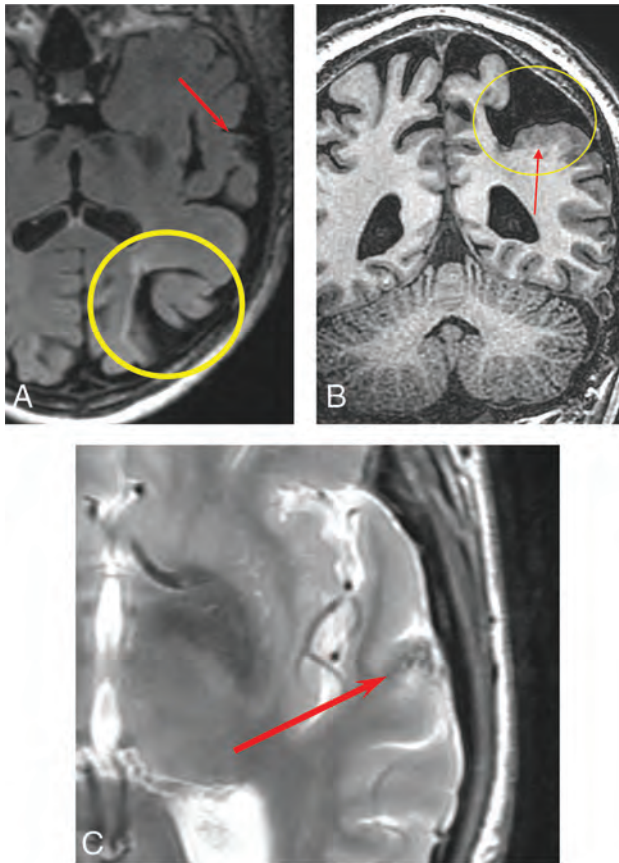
An 80-year-old man with HHT. Axial T2 FLAIR image shows porencephaly with surrounding gliosis (A, yellow circle) and an AVM in the left superior temporal gyrus (A, red arrow). Coronal volume T1 image shows porencephaly (B, yellow circle) partially lined by polymicrogyria (B, red arrow). Axial T2 FSE image shows flow voids associated with a small AVM (C, red arrow).
